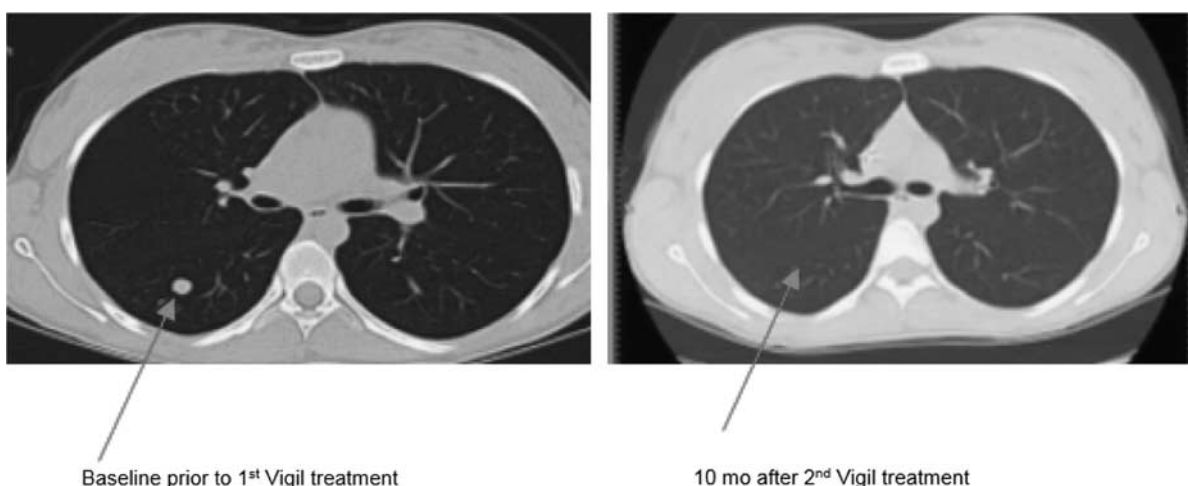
Computerized tomography (CT) scan highlighting one of several progressive pulmonary lesions before first Vigil treatment compared with first CT scan representing complete response 10 months after second Vigil treatment was initiated.
